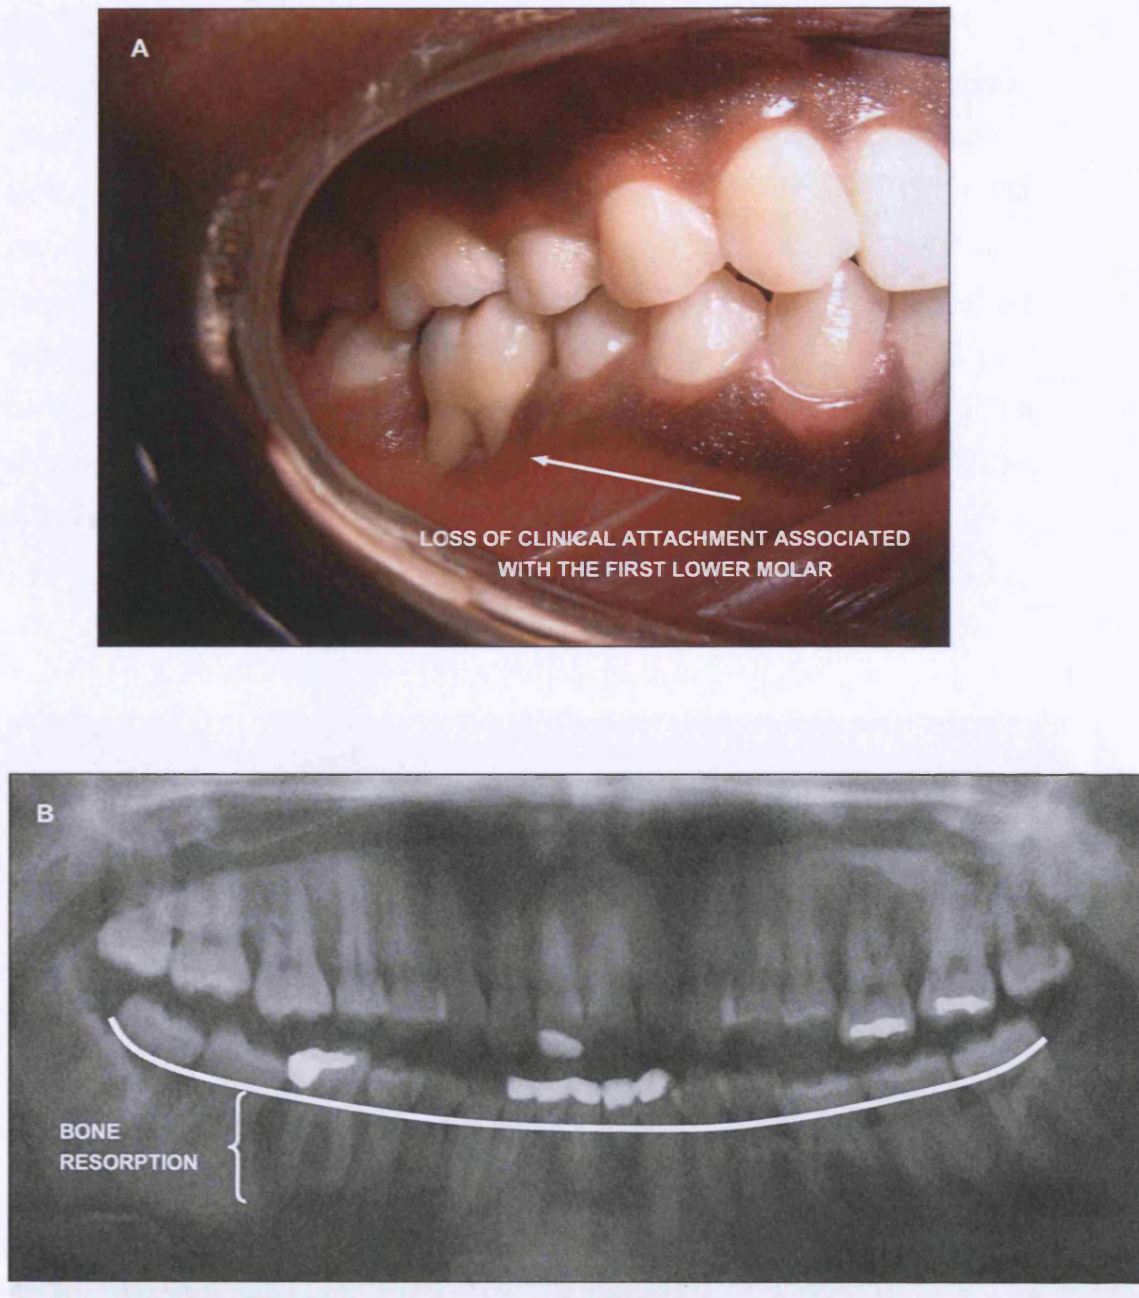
(A) Clinical photograph of local aggressive periodontitis (LAP): In a patient younger than 30 years of age, periodontitis is more pronounced on the first lower right molar. (B) Panoramic radiograph of LAP. Demonstrating bone resorption confined predominantly to the incisors and the first molars. The alveolar bone surrounding the first lower right molar is almost all resorbed. A white line has been inserted to approximately demonstrate where the bone should be in a healthy subject (photographs kindly provided by Luigi Nibali)
